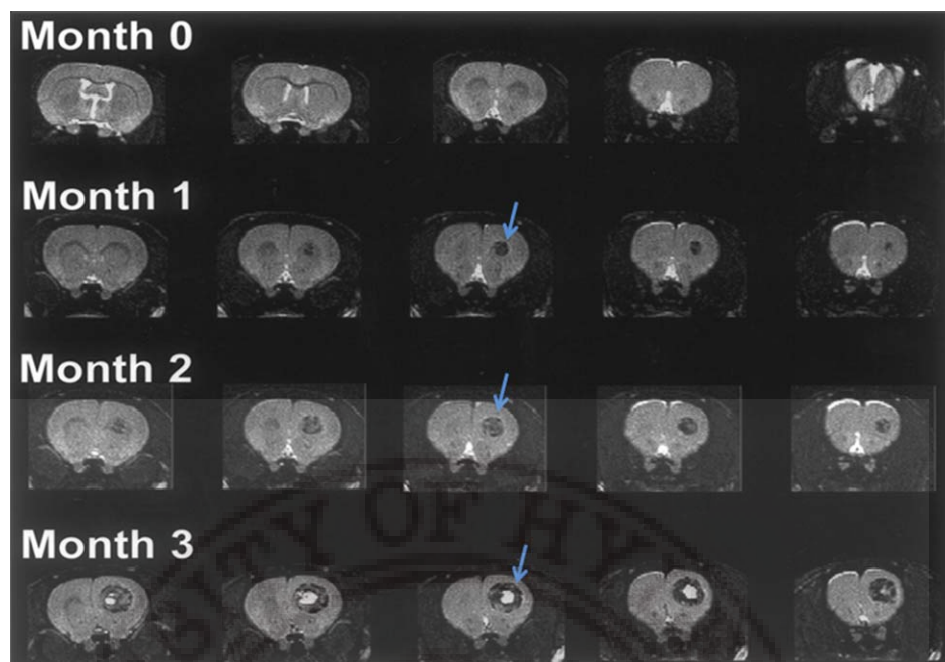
Glioma emergence over time as assessed using MR imaging. Tumors were appeared at the age of 1 month and progressively increased in size over a period of time. (Kish et al, 2001).
